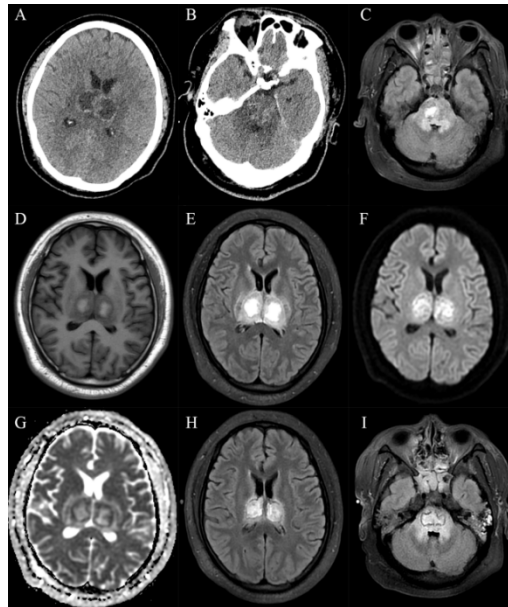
CT and MRI in Patient with typical radiological findings of ANE.
